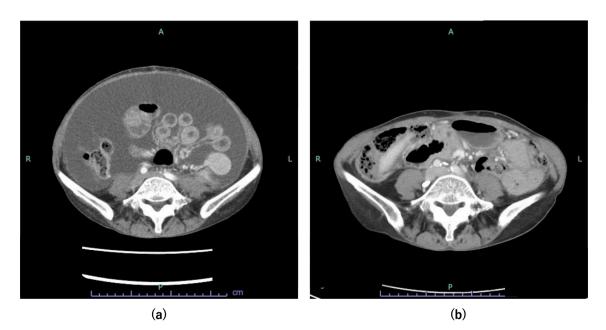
Computed tomographic images of patient. (a) Before lymphangiography, the patient had massive ascites. (b) After lymphangiography, the ascites significantly improved.
